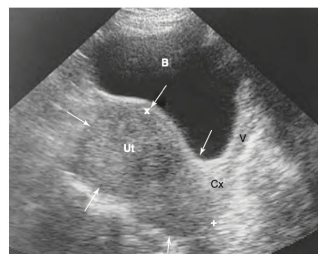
Ultrasonic image of a uterus enlarged and irregularly distorted by multiple fibroids (arrows). Such studies are useful to help rule out ovarian enlargement too. B, Bladder; Cx, cervix; U, uterus; V, vagina. (From Veit RL: *Color atlas of obstetric and gynecologic pathology*, St Louis, 1997, Mosby.)
